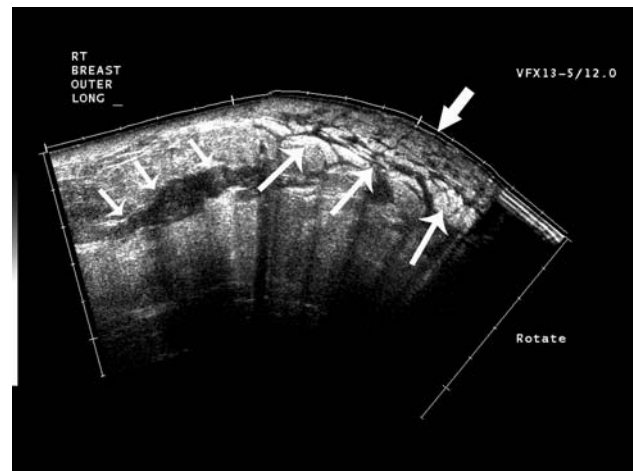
Extended-field-of-view ultrasound of the right breast in the same patient demonstrates marked global skin thickening (broad arrow), subcutaneous edema (medium arrows) and linear dissection through the breast parenchyma (short arrows) representing primary breast parenchymal lesion
